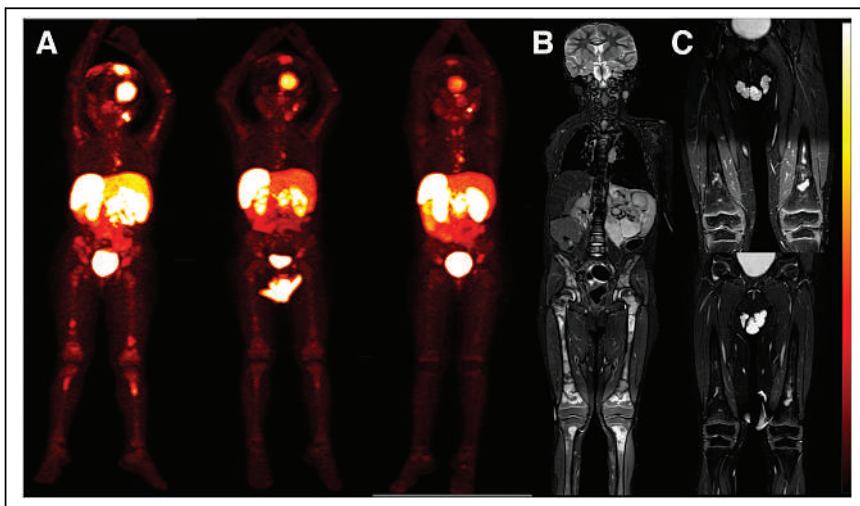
(A) Resolution of bone marrow disease on ^{68}Ga -DOTATATE PET/CT (from left to right: initial staging, 2 mo, and 6 mo). (B and C) Short-tau inversion recovery MRI still showing changes at 6 mo (false-positive MRI) (initial staging [B], 2 mo [C top], and 6 mo [C bottom]).
